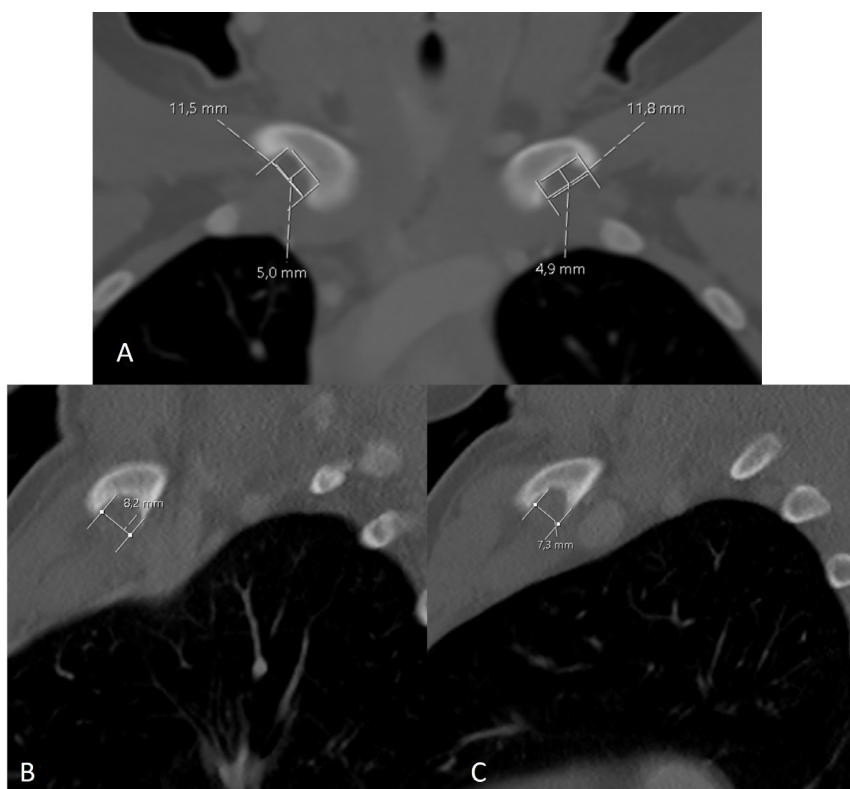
CT imaging of clavicle at the level of the sternoclavicular joint. (A) coronal reformat image and (B) and (C) sagittal reformat images; shows RF measurements.
